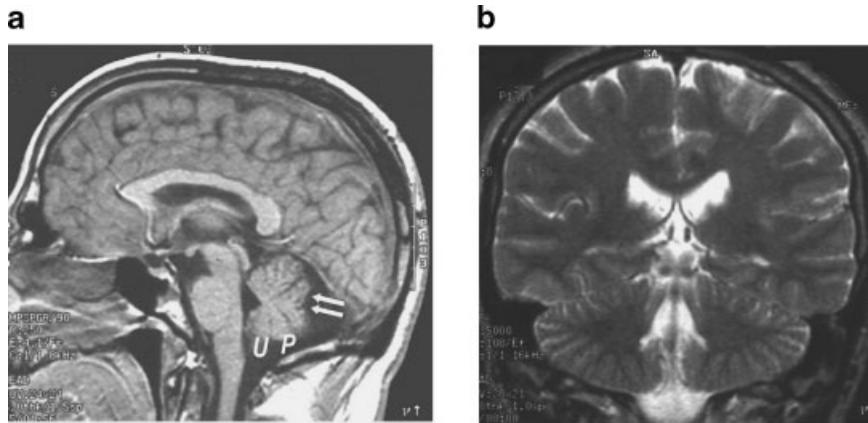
Representative sagittal T1-weighted (a) and coronal T2-weighted (b) MRI images from patient 1, showing an enlarged basal cistern due to a postero-inferior cerebellar vermis hypoplasia. Folium and tuber are most obviously affected (arrowheads) than pyramid (P) and uvula (U).
